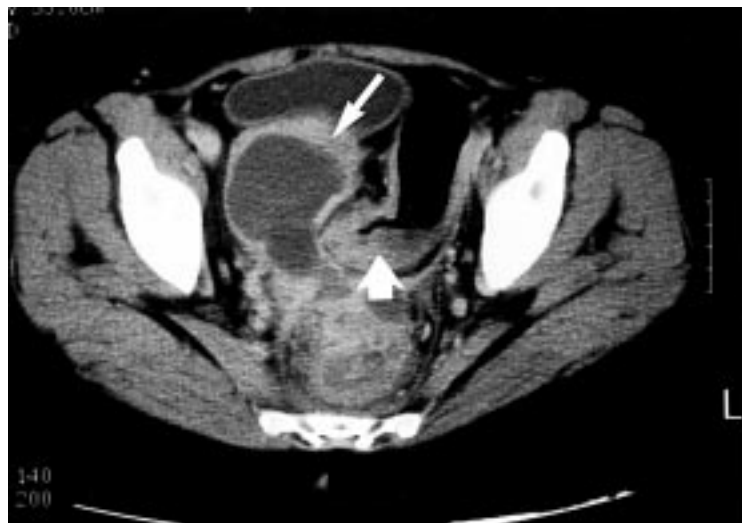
Abdominal computed tomogram.
